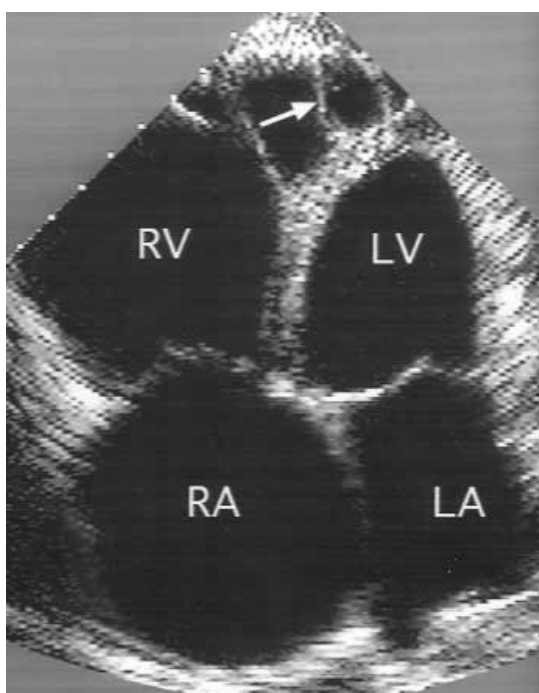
Transthoracic echocardiography in the apical 4-chamber view reveals a severely enlarged right atrium (RA) and right ventricle (RV). Note the heavy trabeculation and multiple septations with thinning of the right ventricular apex (*arrow*), which wraps around the left ventricular apex. LV, Left ventricle; LA, left atrium.
